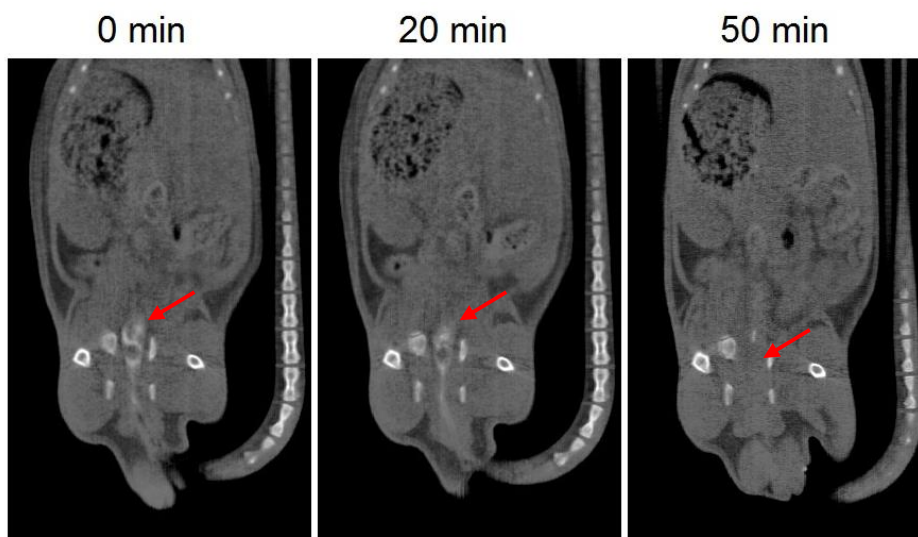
CT images of 3D printed suppositories with barium sulphate. The red arrow indicates the location of the suppository (white colour).
